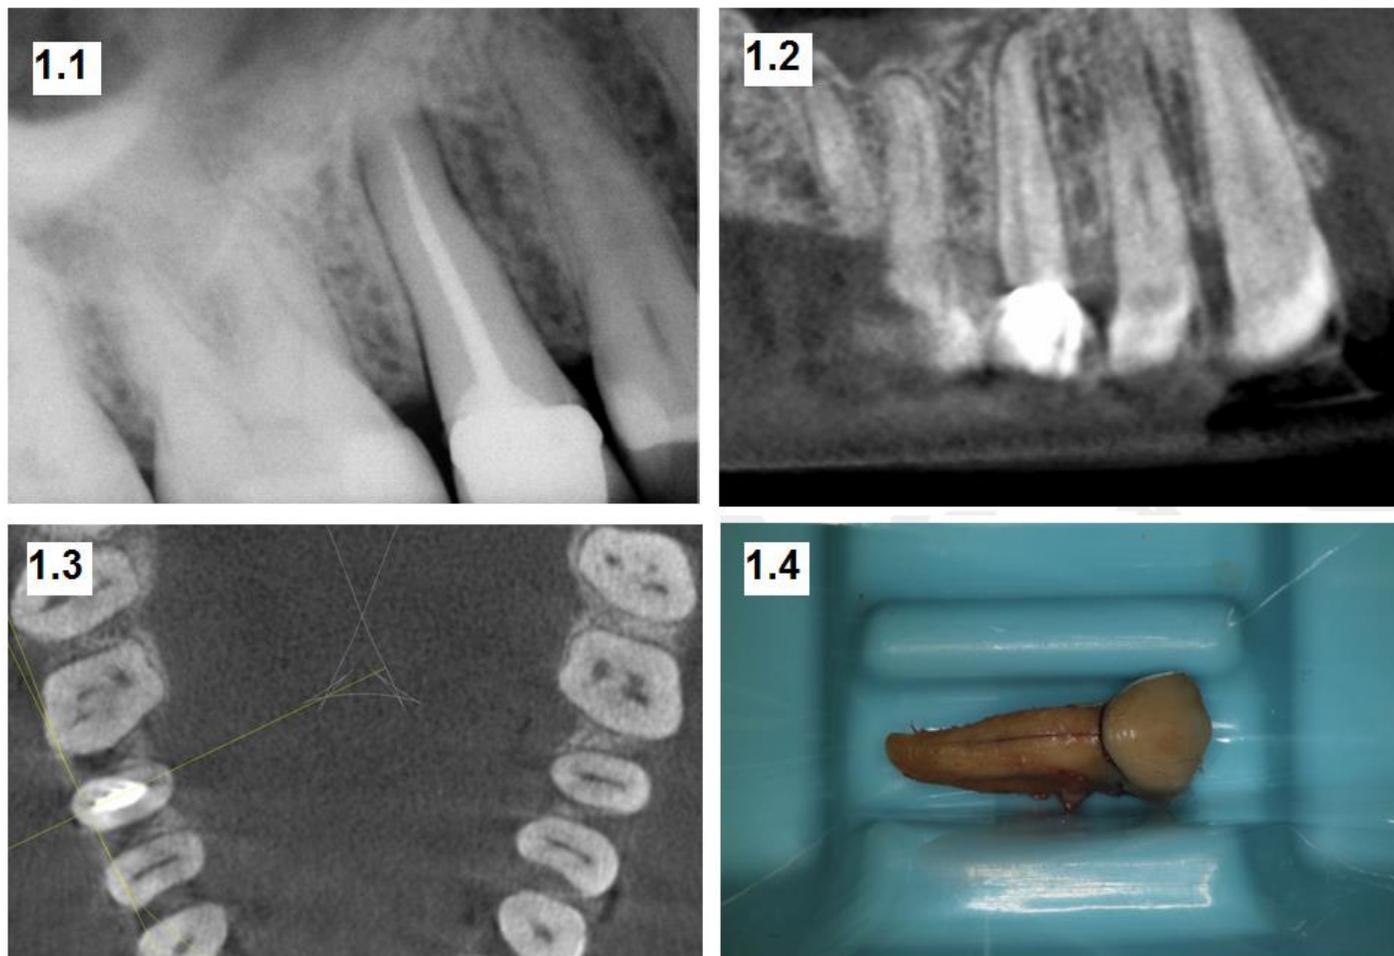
1.1. Diagnostic radiograph; Fig: 1.2. CBCT Image longitudinal section showing fracture line; Fig: 1.3. Axial section of CBCT Image showing fracture; Fig: 1.4. Fracture evident after extraction
